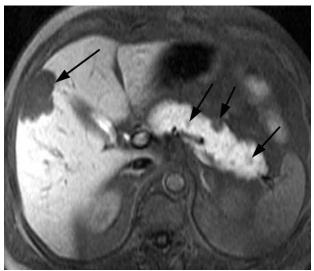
T1w MRI of liver and pancreas before (A), and T1w fatsat MRI after (B) administration of Mangafodipir. Both normal liver and pancreas tissue are enhanced after injection of manganese, with better delineation of focal lesions in both liver and pancreas (arrows). Images courtesy of Dr Dushyant Sahani, Department of Radiology, Massachusetts General Hospital, Boston, MA, USA.
